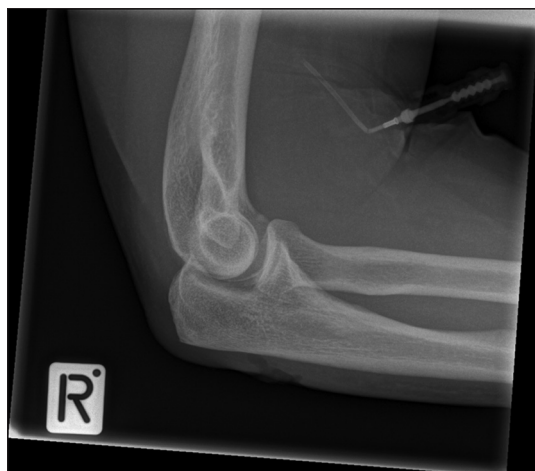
Lateral view X-ray showing the kinked intravenous catheter
